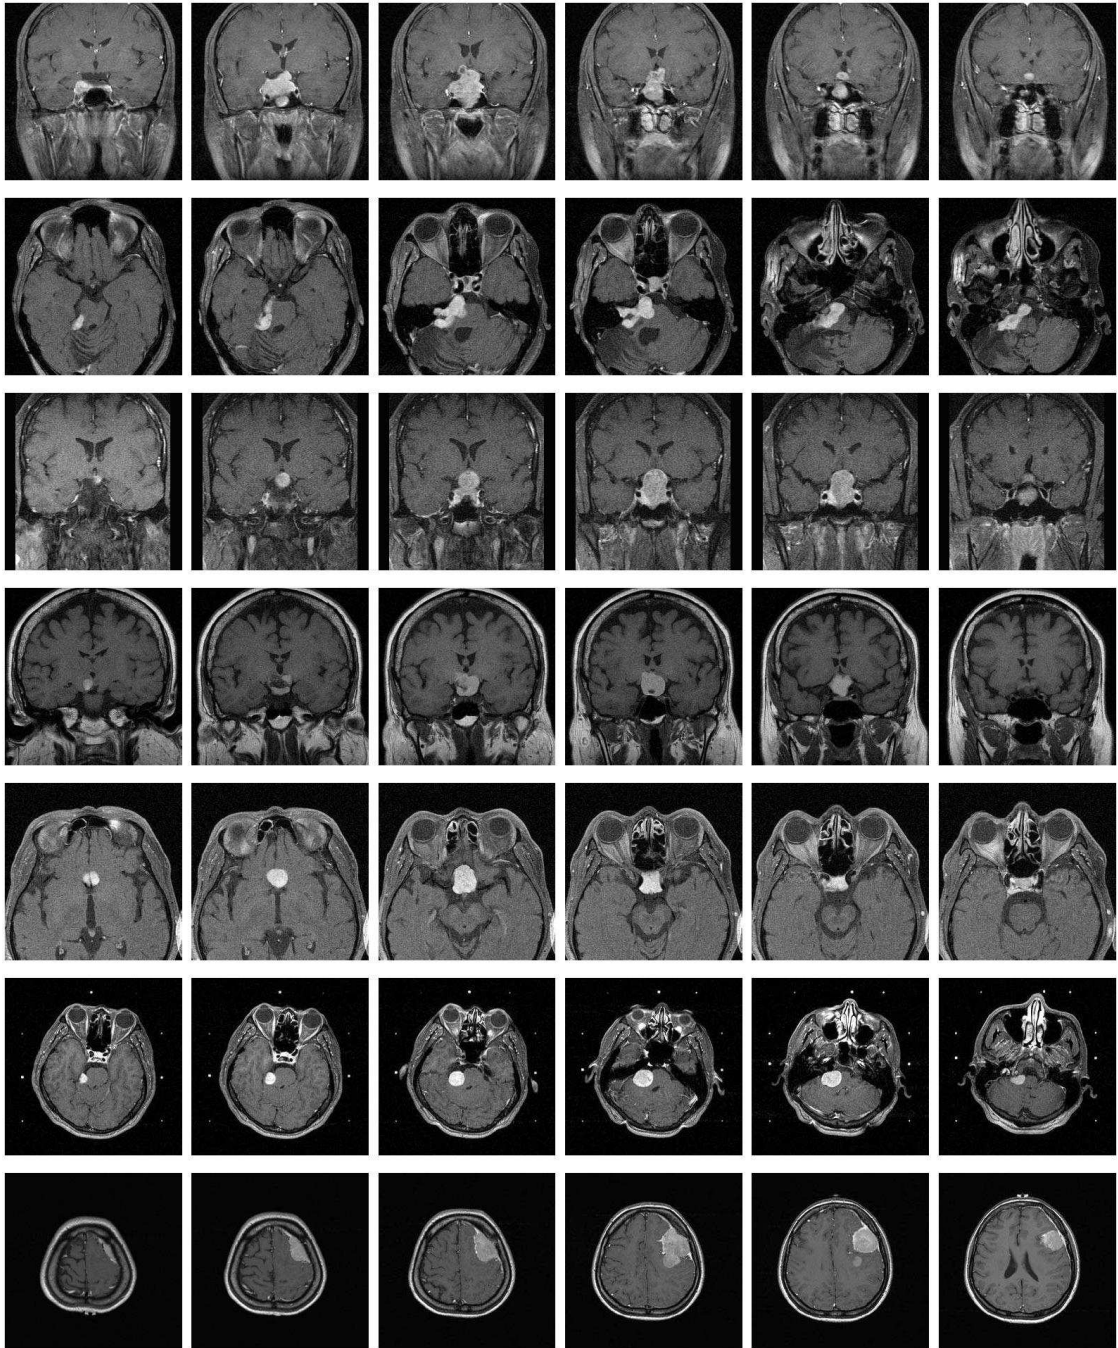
Some slices of 3D MR images in the dataset. The indexes of MR images from top to bottom are: 2, 3, 5, 6, 8, 11, and 13.
